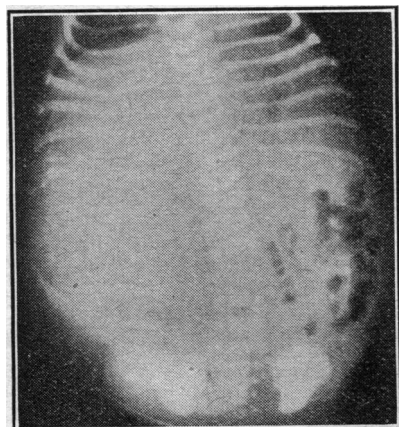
Case 1. A.P. radiograph taken when the patient was 5 hours old.
